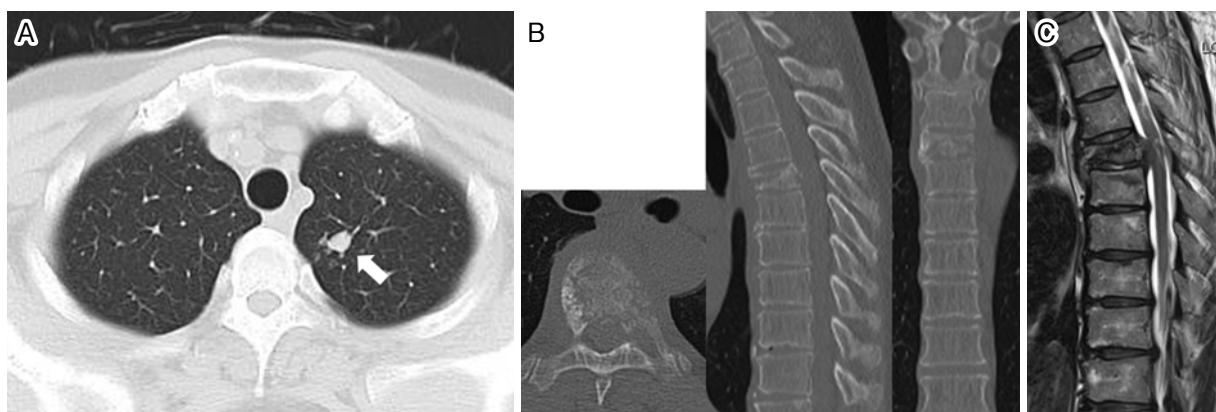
Preoperative imaging. A) Axial computed tomography (CT) of the chest. White arrow shows a nodular shadow in the upper lobe of the left lung. B) CT of the thoracic spine. Pathological fracture is evident at T6. C) Preoperative sagittal T2-weighted magnetic resonance imaging. Epidural abscess is seen compressing the spinal cord.
